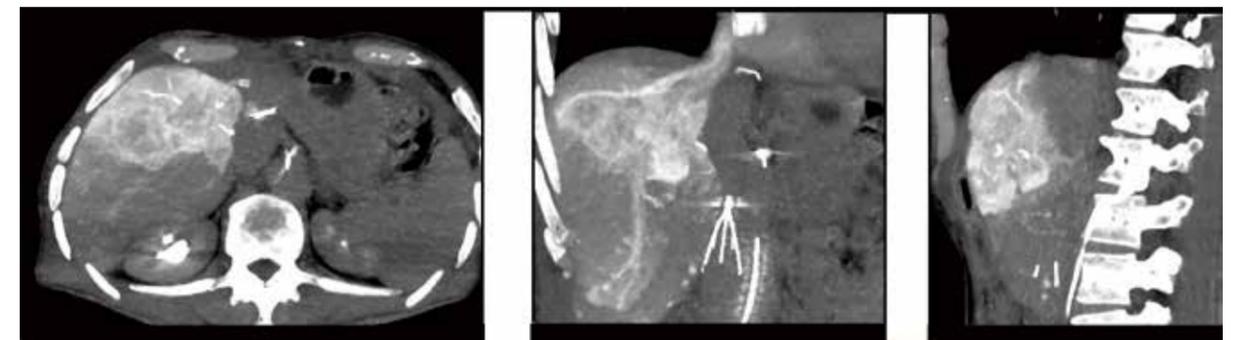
Helical CT with injection through 2.4 French microcatheter placed in the common hepatic artery. Venous phase of axial, coronal, and sagittal MPR highlights contrast washout of the tumor area.
